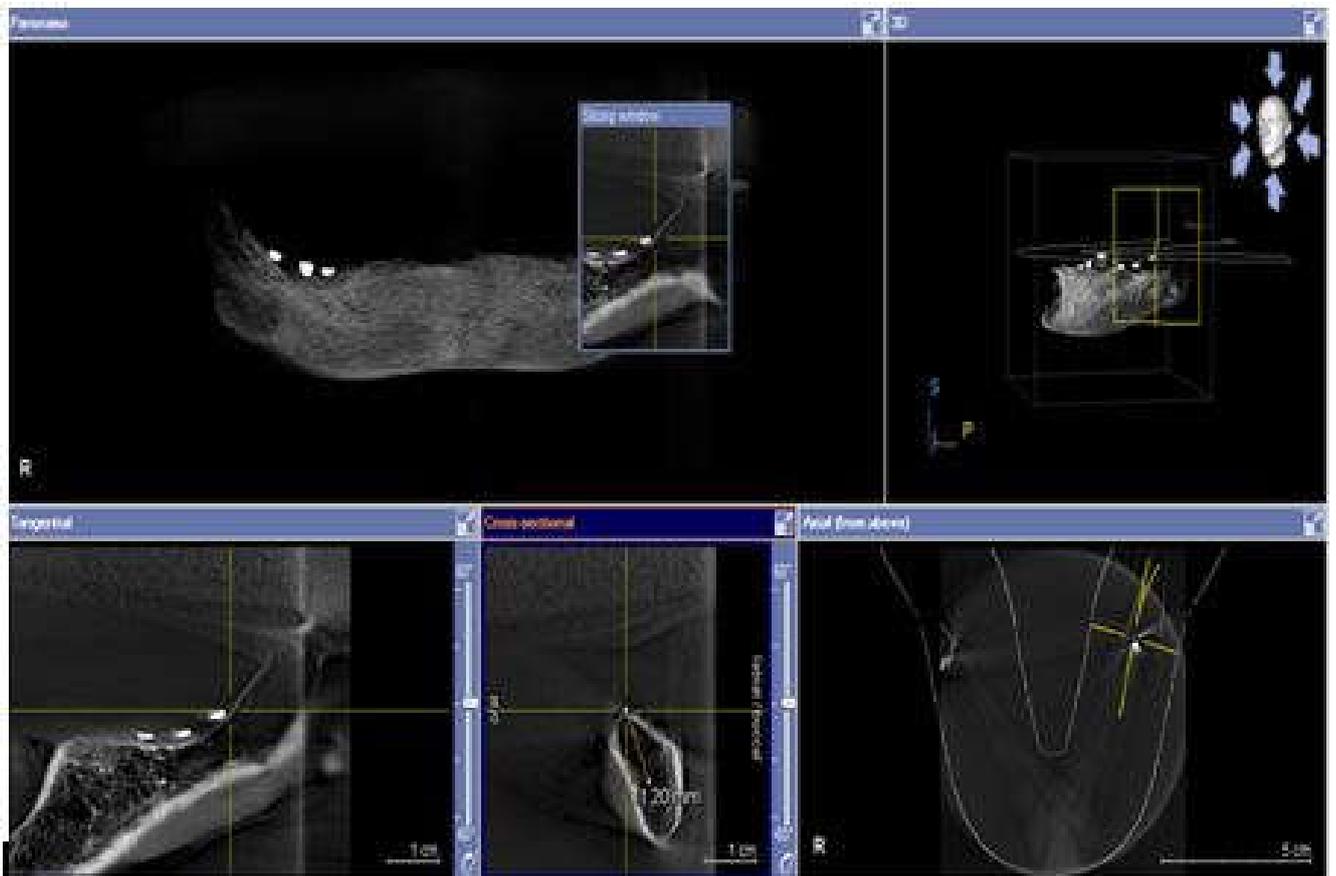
Radiographic length measurement using CBCT software
